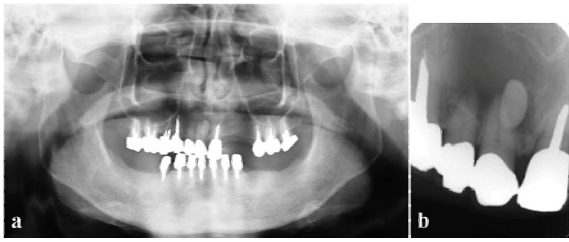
Panoramic radiographs revealed a well-defined, round, radiolucent lesion including an impacted supernumerary tooth at the midline maxillary region.
